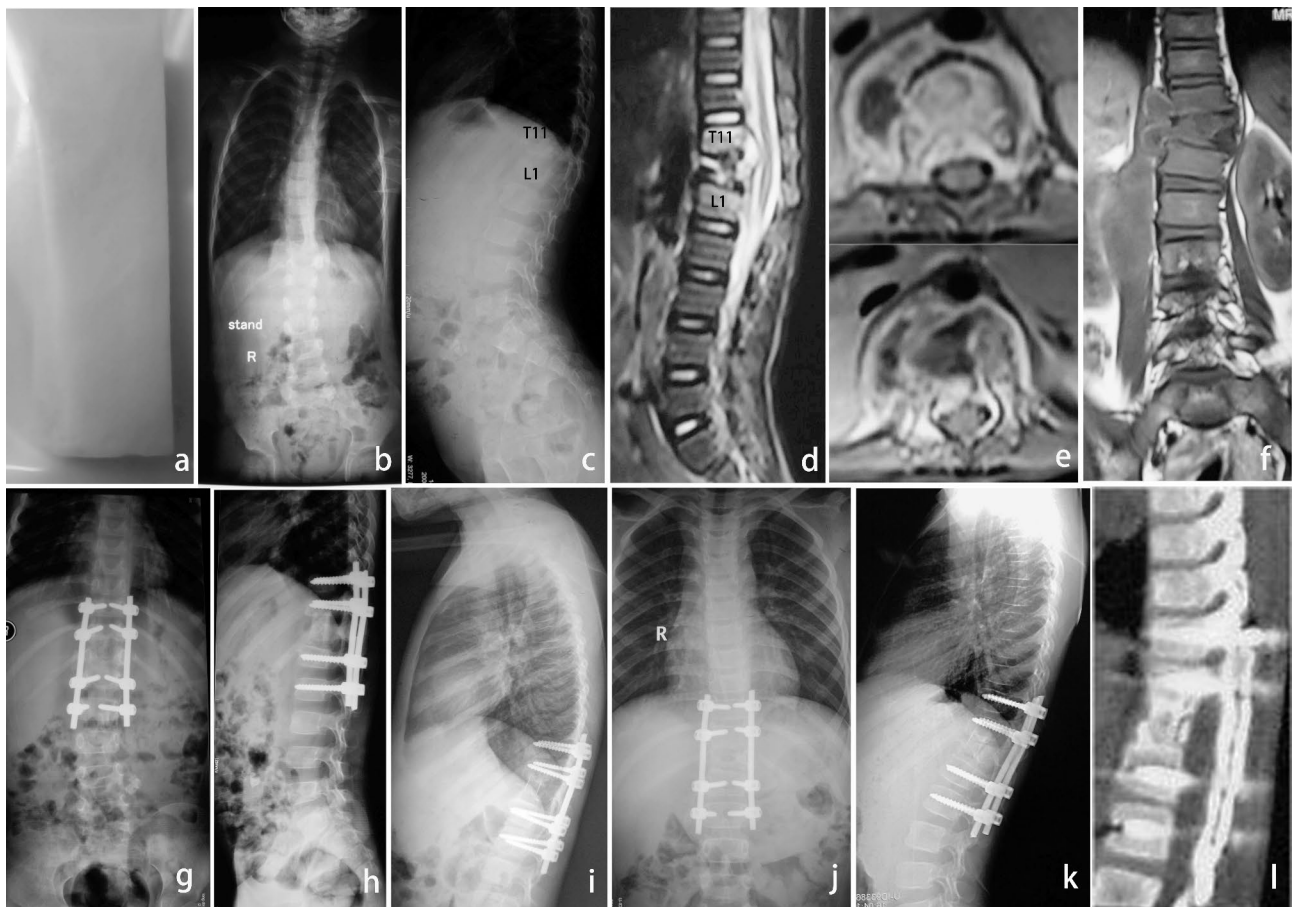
(a) Allogenic strut bone; (b-f) Preoperative images of a 7-year-old boy showing severe destruction of the T12 vertebral body with kyphosis, spinal cord compression, and abscesses; (g-h) Posterior instrumentation, anterior debridement, and fusion were performed using allogenic strut bone; postoperative X-ray showed favorable kyphosis correction; (i) Twenty-month postoperative X-ray showing a good internal fixation position; (j, k) Coronal and sagittal alignment were satisfactorily maintained 28 months postoperatively; and (l) A solid fusion was obtained
